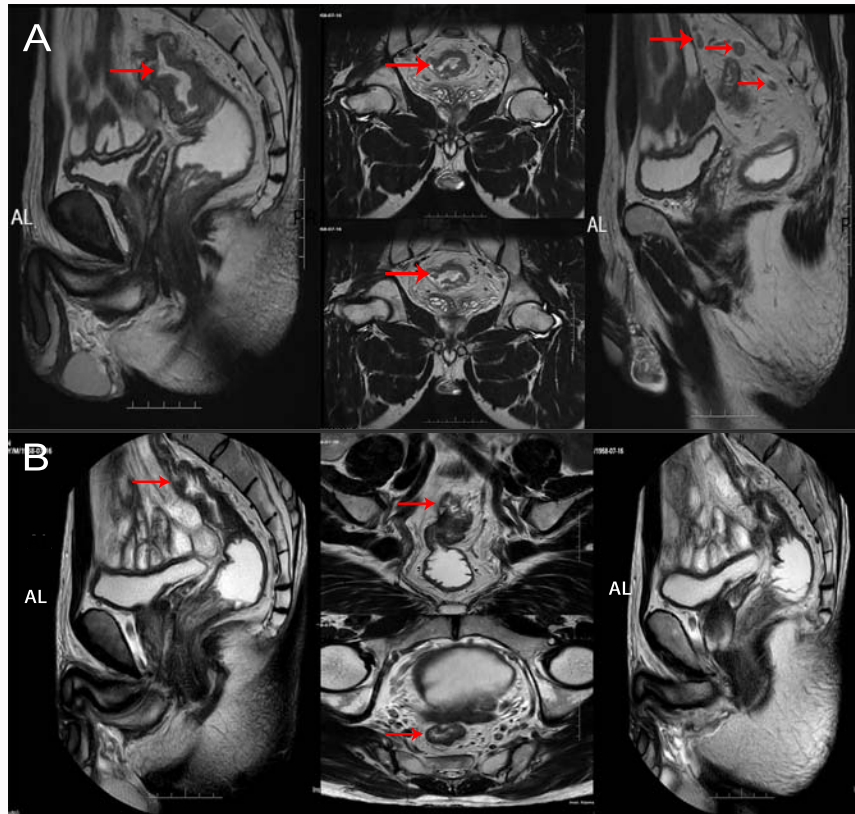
The examination of MRI. A) The MRI before 3 courses of chemotherapy with CAPOX. B) The MRI after 3 courses of chemotherapy (AL: Long-Axis Position).
